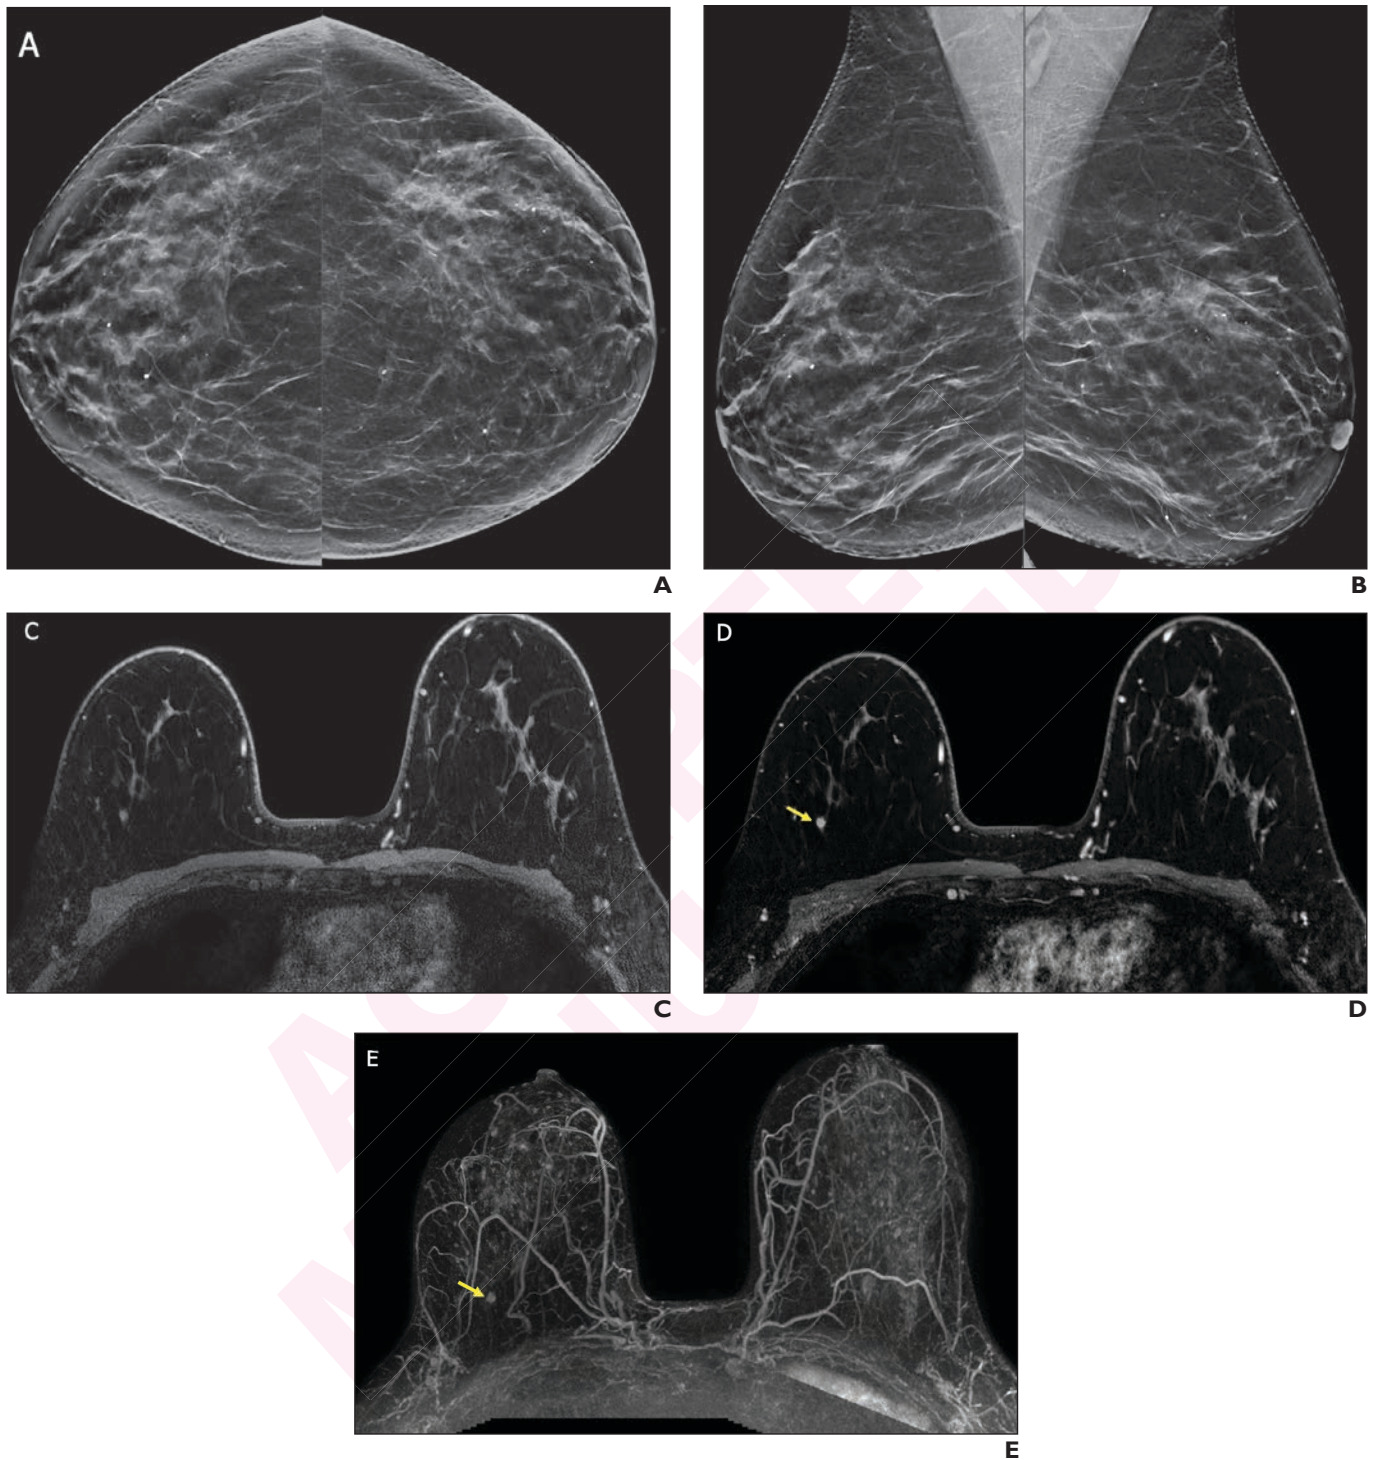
Cancer seen only on screening abbreviated MRI in a 69-year-old woman with dense breasts and history of lobular carcinoma in situ excised two years prior. A) CC and B) MLO synthetic 2D views from screening DBT demonstrate heterogeneously dense breasts with no abnormalities. C) Baseline screening abbreviated MRI, consisting only of a noncontrast 3D T1-weighted acquisition and D) a single post-contrast T1-weighted 3D acquisition, from which E) subtracted maximum intensity projection image is created, demonstrates an enhancing round mass with indistinct margins and heterogeneous internal enhancement in the upper outer right breast (arrows) measuring 0.6 cm. MRI-guided biopsy and excision confirmed a 0.6 cm grade 1 IDC, ER/PR positive, Her2/neu negative, with negative sentinel node biopsy.
